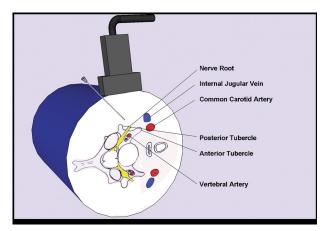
Cross-sectional anatomy at the C6 level in the lateral decubitus position, with the probe positioned the short-axis transverse orientation. Needle advancement in an in-plane approach from posterior to anterior. Under color Doppler sonography, the underlying arterial and venous blood flow can be visualized.
